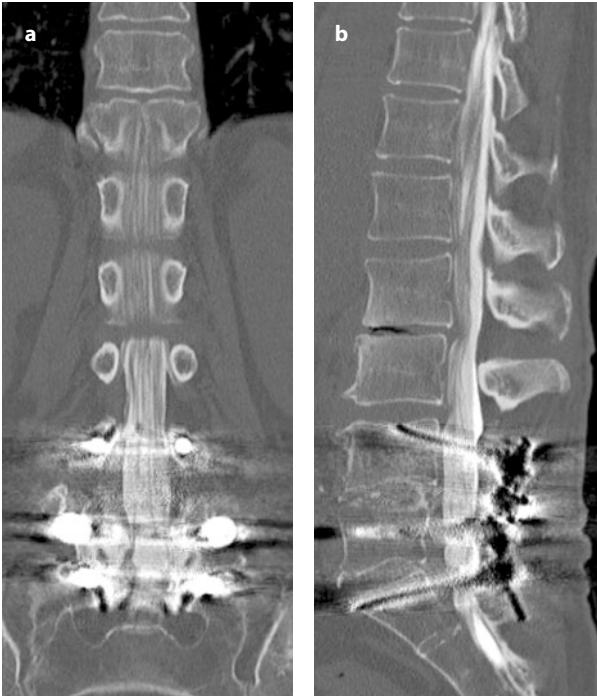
Myelo-CT of the lumbar spine with coronal (a) and sagittal (b) views in the patient described in Fig. 2.3 demonstrate that, despite metal artifacts from the hardware, good assessment of the lumbar nerve roots (a) is possible. Sagittal image (b) demonstrates a degenerated bulging disk with vacuum phenomena and mild impingement of the thecal sac at the level of the L2–L3 intervertebral disk space and a bulging disk at the L3–L4 level
